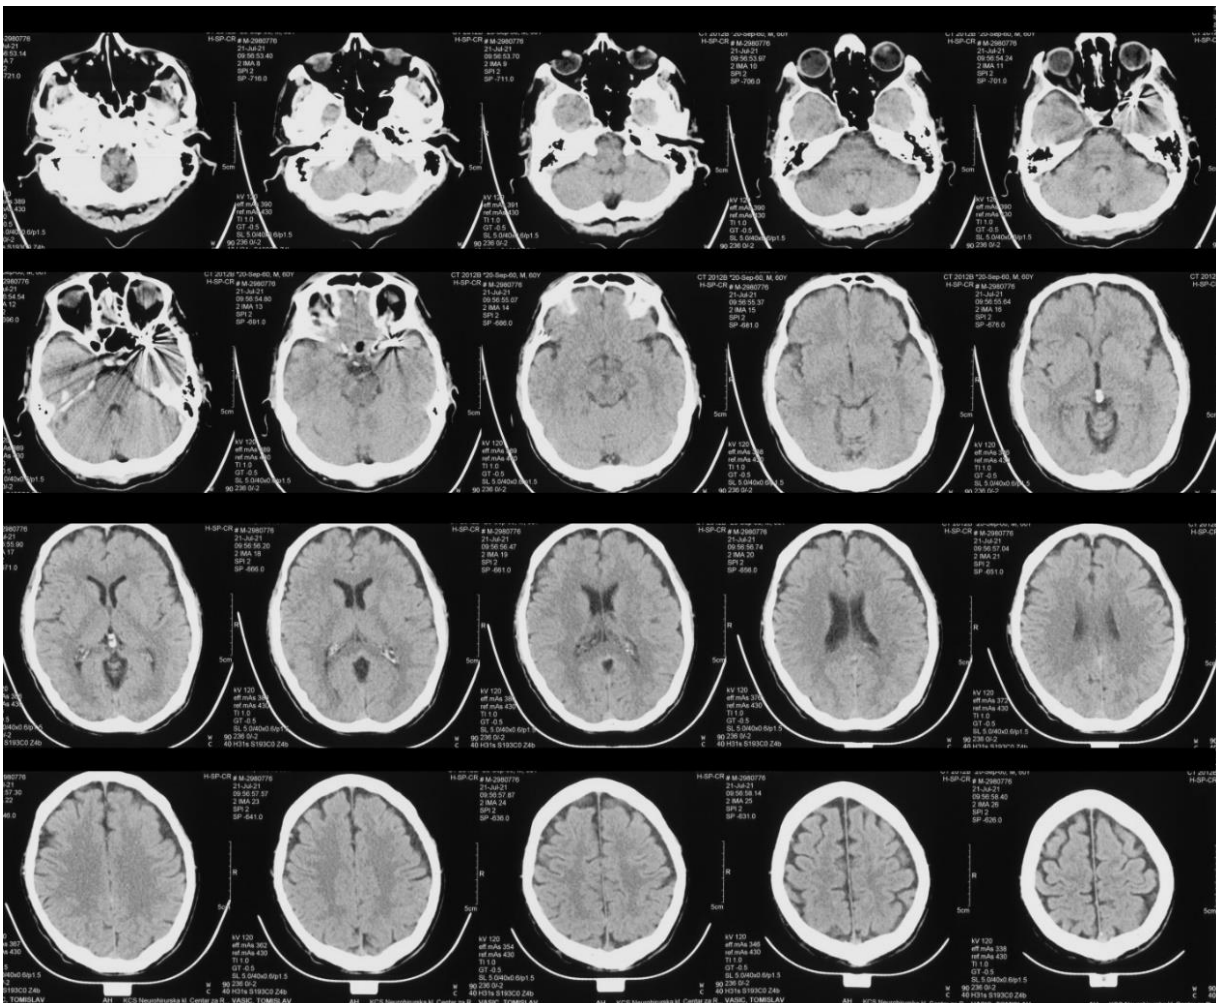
Control CT scan showed no signs of rehemorrhage, ischemic lesions or hydrocephalus.
